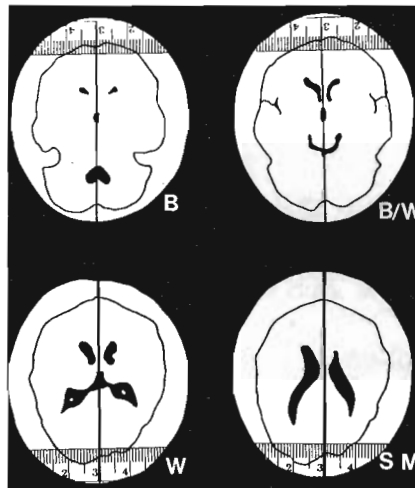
Method for measuring computed tomographic scan occipital widths (bottom) and frontal widths (top). In this case, occipital width asymmetry on slice W was 3-mm difference, with left greater than right. Asymmetry value was +30. Asymmetry value on slice SM was +10. Similar methods were employed in measurement and calculation of frontal widths on slices B and B/W, and of posterior parietal widths on slices SM + 1 and SM + 2.
